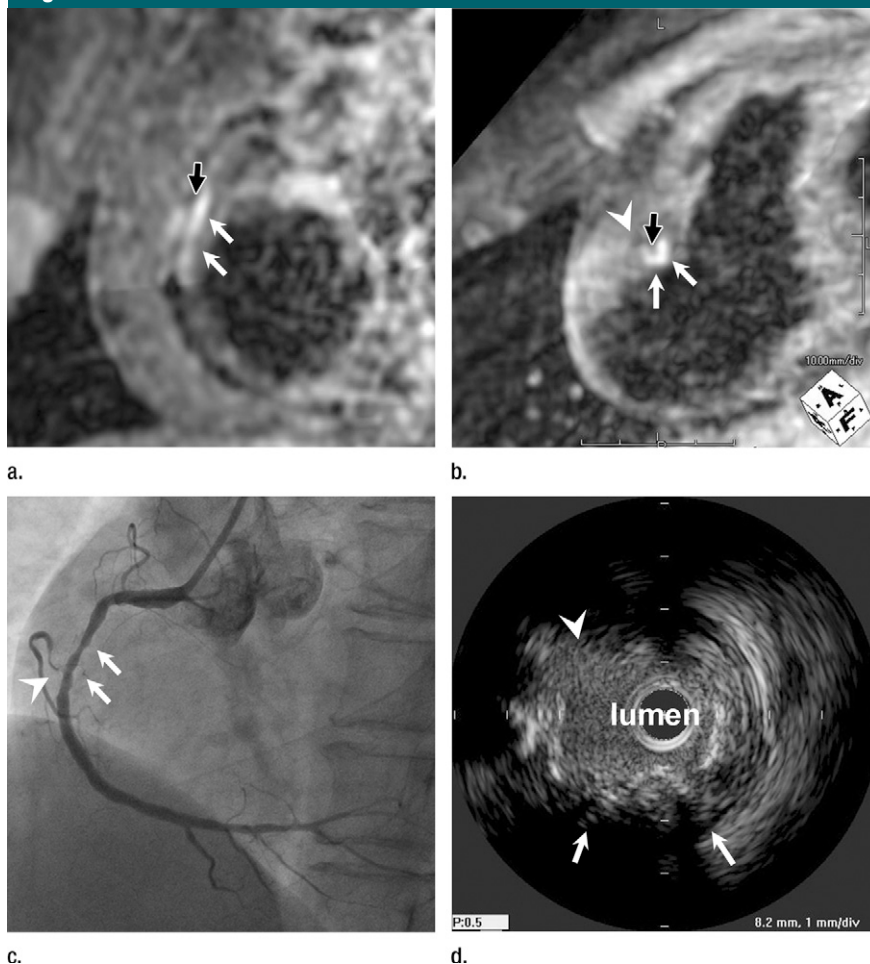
Black blood T1-weighted 3D whole-heart coronary images acquired with 3.0-T MR imager and 32-channel cardiac coils in a 71-year-old man with chest pain. T1-weighted 3D turbo spin-echo pulse sequence was used with 1 R-R interval/39 msec; flip angle, 90°; SENSE factor, four; field of view, 320 × 256 × 140 mm; acquisition matrices, 192 × 154 × 80; reconstruction matrices, 512 × 512 × 160). (a) Multiplanar reconstructed image of the right coronary artery exhibits high signal intensity along the coronary vessel wall in the middle portion of the right coronary artery (white arrows). Black arrow (also for b) indicates lumen of the right coronary artery. (b) Cross-sectional MPR image of the right coronary artery shows high-signal-intensity plaque (white arrows) in the right coronary artery located on the opposite side of the right ventricular branch (arrowhead). (c) Conventional coronary angiogram shows moderate coronary artery stenosis. (d) Cross-sectional intravascular US image shows eccentric soft plaque in the middle portion of the right coronary artery (arrows). Arrowheads on b, c, and d indicate position of right ventricular branch of the right coronary artery. (Reprinted, with permission, from reference 69.)
